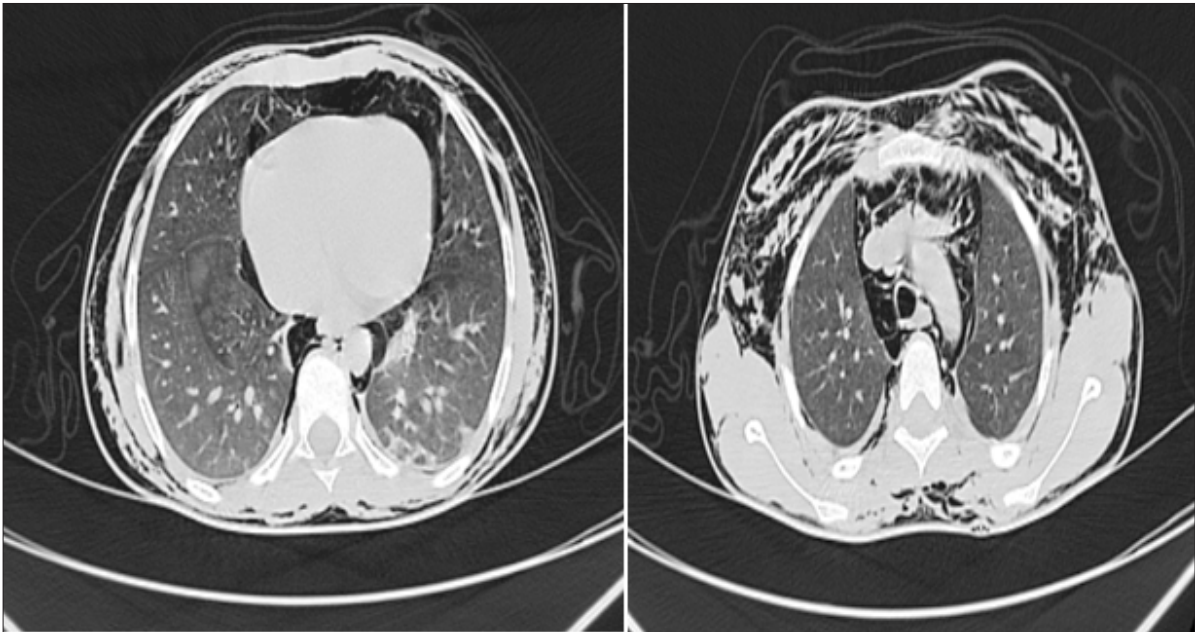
axial sections of chest CT-scan shows air in the mediastinum compartments and subcutaneous tissue of the Thorax
